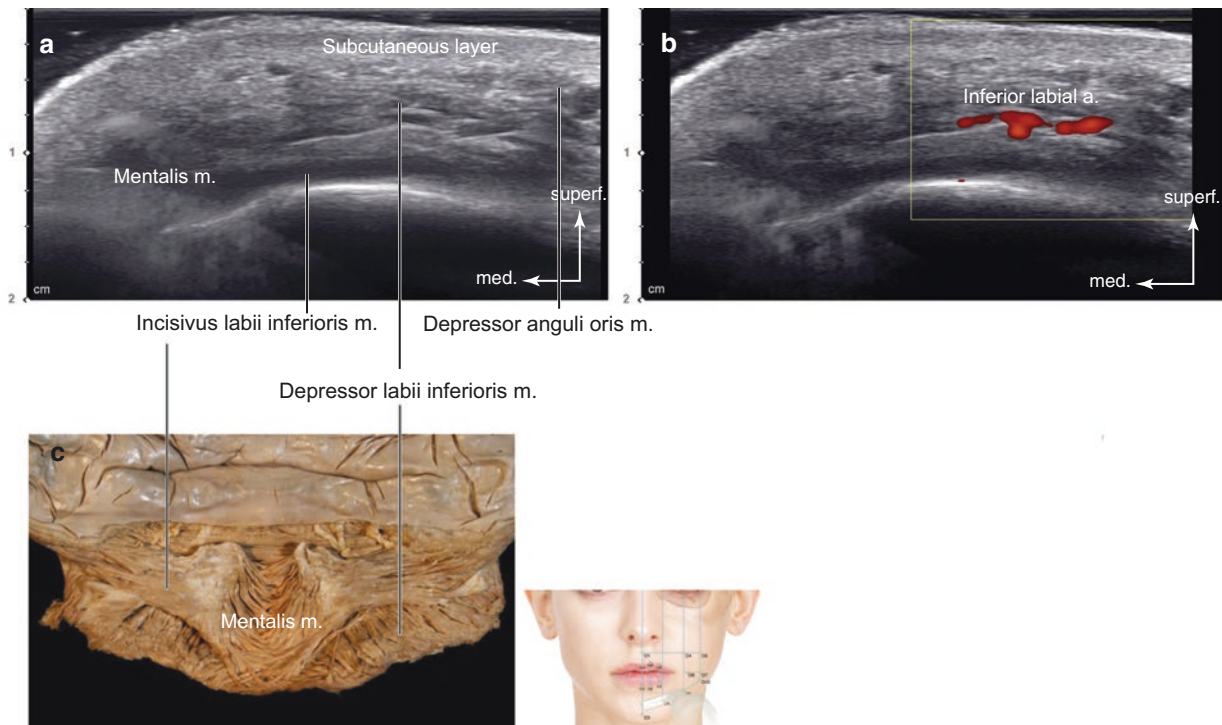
Ultrasonography of the intersection point of TL8 and PL1 (O8). (a) B mode (transverse view, 15 MHz by linear transducer), (b) Doppler mode (transverse view, 15 MHz by linear transducer), and (c) posterior aspect of the dissected mentalis muscle. Medial fibers of the mentalis muscle forming a dome-shape chin prominence. (Published with kind permission of © Hee-Jin Kim 2020. All Rights Reserved)
